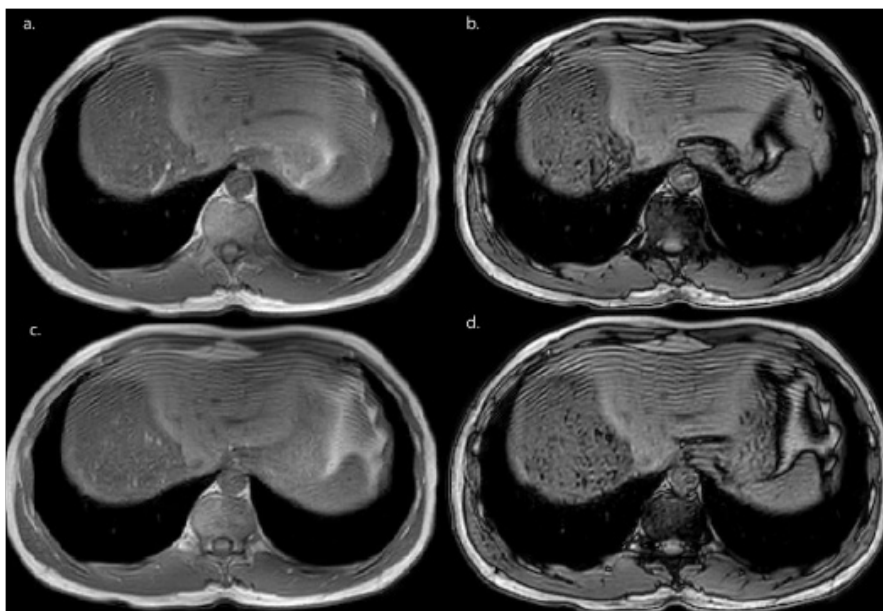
Axial T1-weighted gradient-echo in-phase MR images (a, c)
